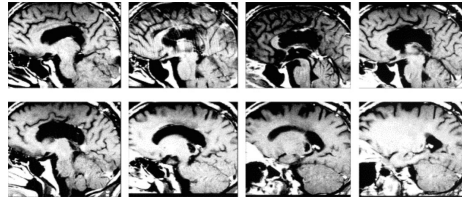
T1 weighted MRI images. Sagittal slices are ordered from right-to-left demonstrating damage to the corpus callosum and to the left posterior thalamus. Reprinted from Goldenberg et al (2001) by permission of Elsevier.
